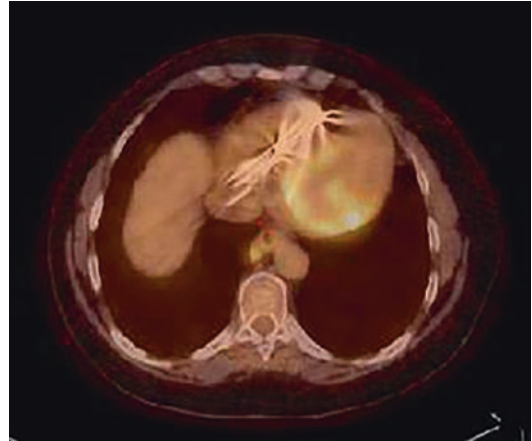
PET CT demonstrating cardiac sarcoidosis that was not apparent on echocardiogram or cardiac MRI
